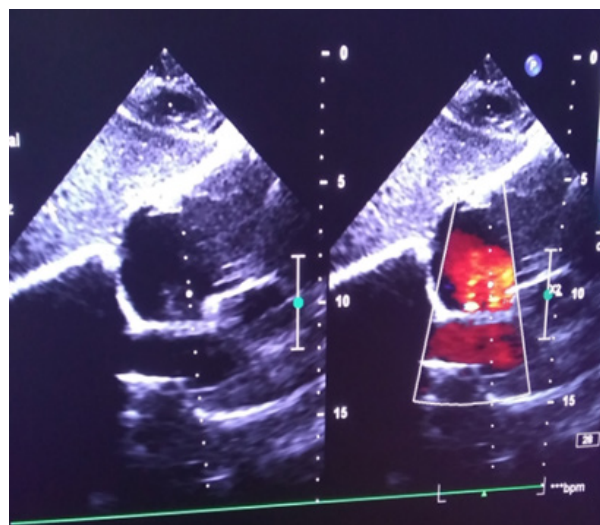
Transthoracic echocardiogram. A fenestrated atrial septal defect is observed.
